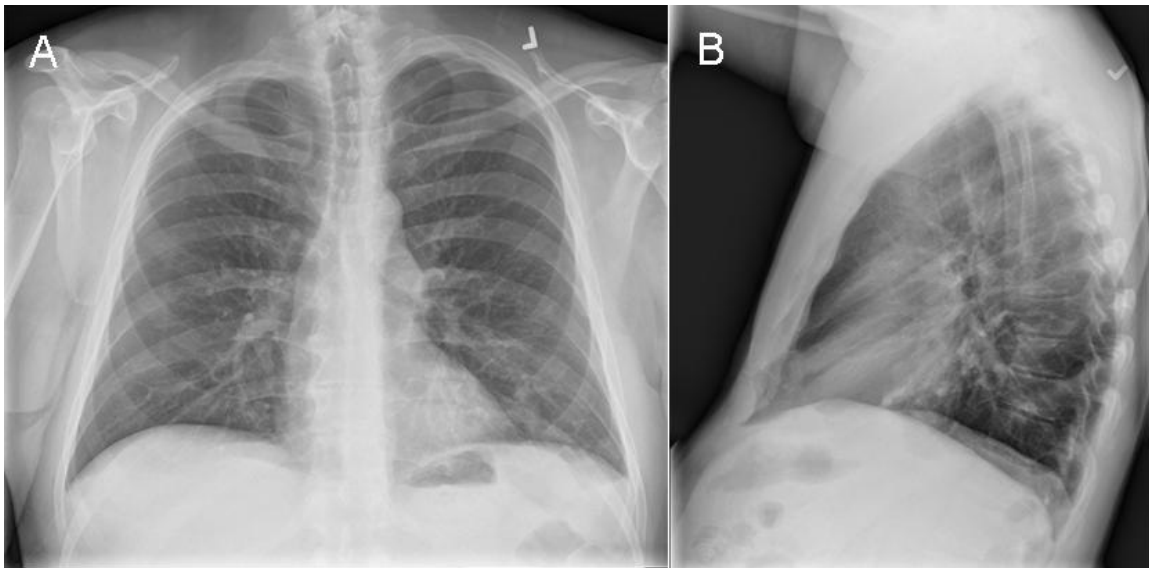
PA (Panel A) and lateral (Panel B) chest x-ray.
